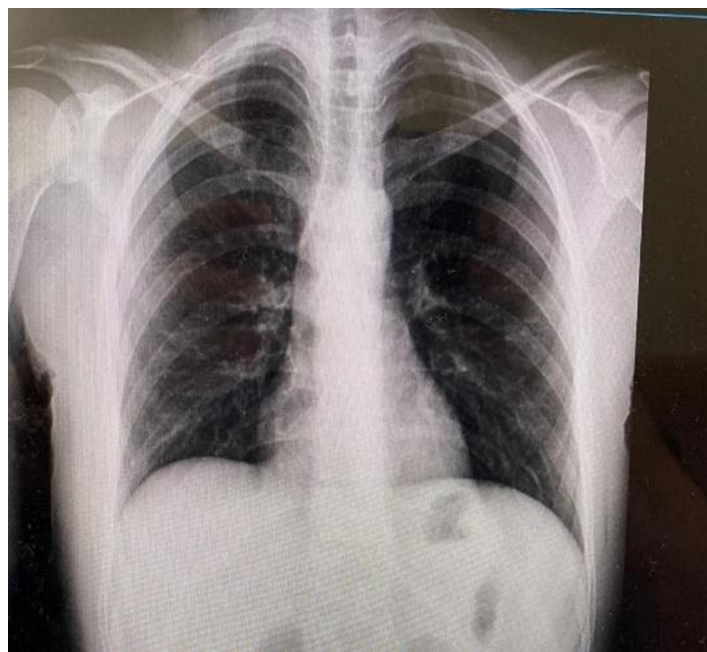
Pre-operative normal PA chest radiography
